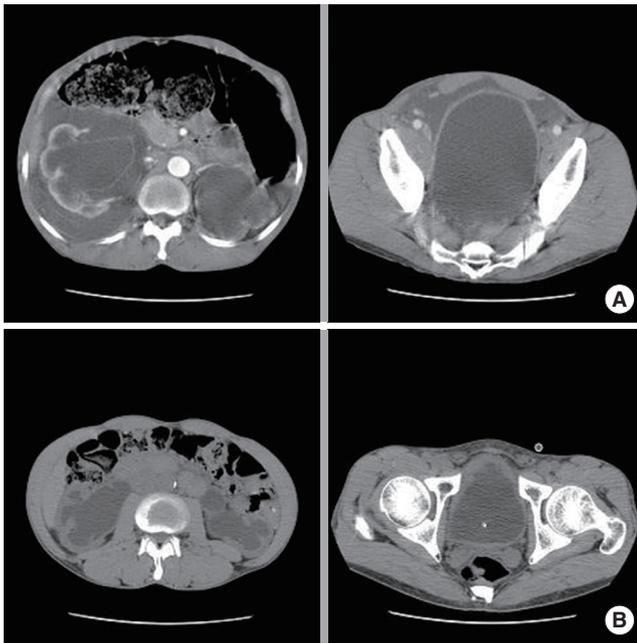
(A) Abdominal computed tomography (CT) which was taken 3 days after right flank pain; Fluid collection was seen in retroperitoneal space and pelvic cavity. (B) Abdominal CT which was taken 6 days after indwelling urethral catheter; Even though bilateral hydronephrosis was still seen, fluid collection in retroperitoneal and pelvic cavity was completely resolved and bladder wall thickening was observed.
